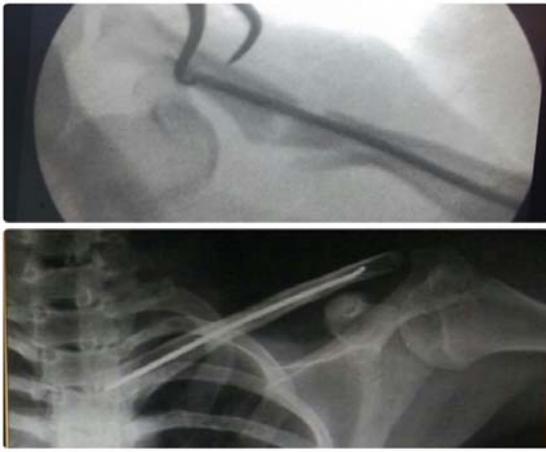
radiographs showing-Per-op manipulation of lateral fragment using towel clip-follow-up 6 months healed fracture.
